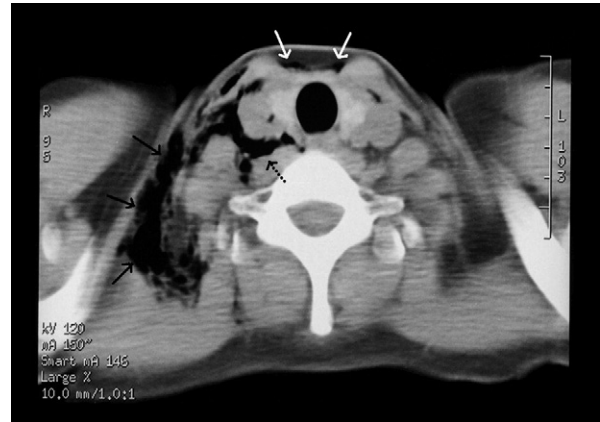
CT scan at the level of the thyroid gland. Air can be observed in the carotid space (black arrows), retropharyngeal space (dotted black arrow), and pretracheal space (white arrows).
